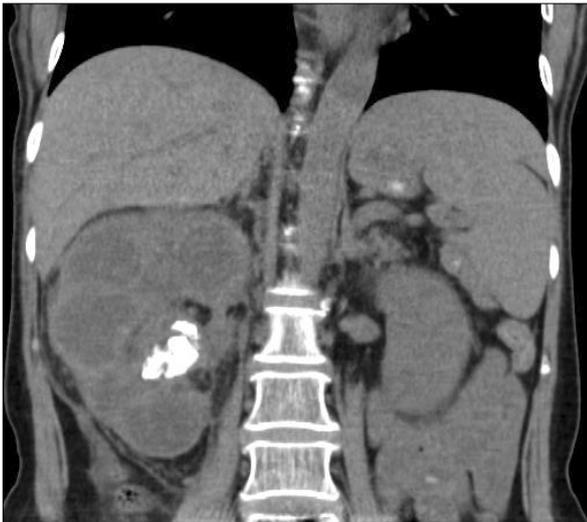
Non-contrast enhanced computed tomography of the kidney showing hydronephrosis and radiopaque lesion on pelvocalyceal system of the right kidney.
